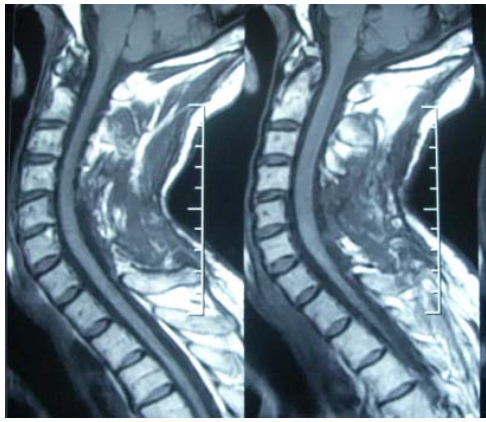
MRI of cervical spine (post operative) shows evidence of laminectomy and decompression of spinal cord.
